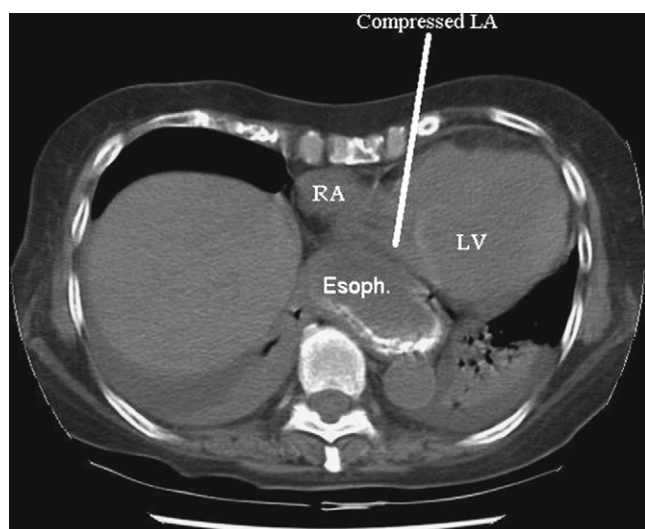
CT of the chest, showing extrinsic compression of the left atrium by massively dilated esophagus.
